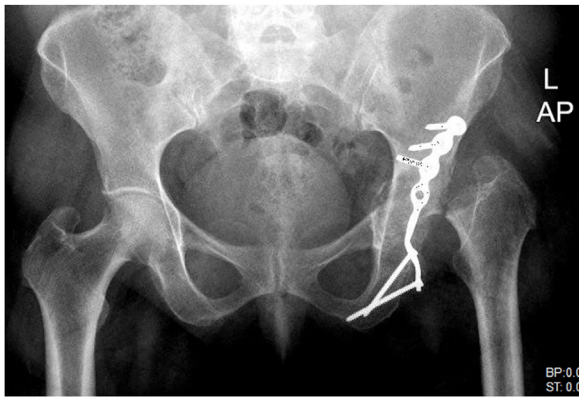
Case 1; Anteroposterior and lateral pelvis radiographs demonstrating left hip post-traumatic arthritis.
